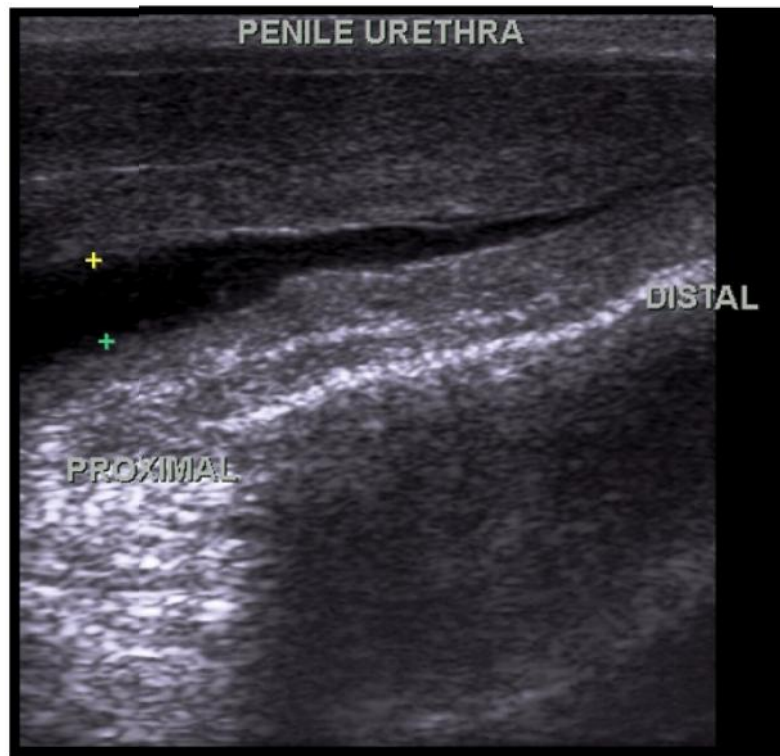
Normal sonographic anatomy of male penile urethra distended with sterile saline (longitudinal view).
